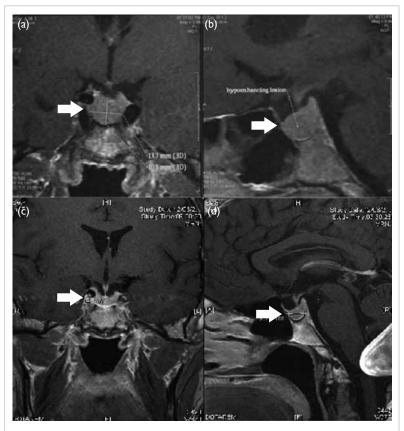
(a, b) T1-weighted magnetic resonance imaging (MRI) of the pituitary gland shows a $1.3 \times 1.0 \times 1.1$ cm (transverse x height x anteroposterior) lesion in the central anterior part of the gland (arrows). (c, d) Repeat MRI of the pituitary gland 17 months after the right lower lobectomy shows that the gland has decreased in size (arrows) compared with the previous one with no more structural lesion
